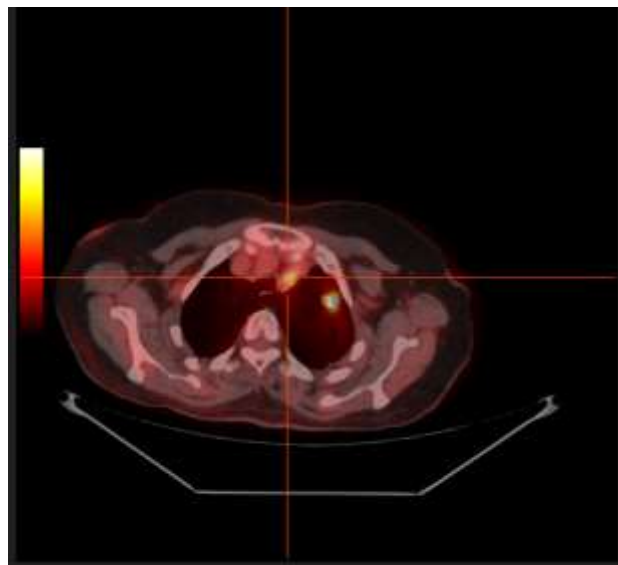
axial section of the PET with 18 F_FDG showing hypermetabolism of the left upper paratracheal lymph nodes
